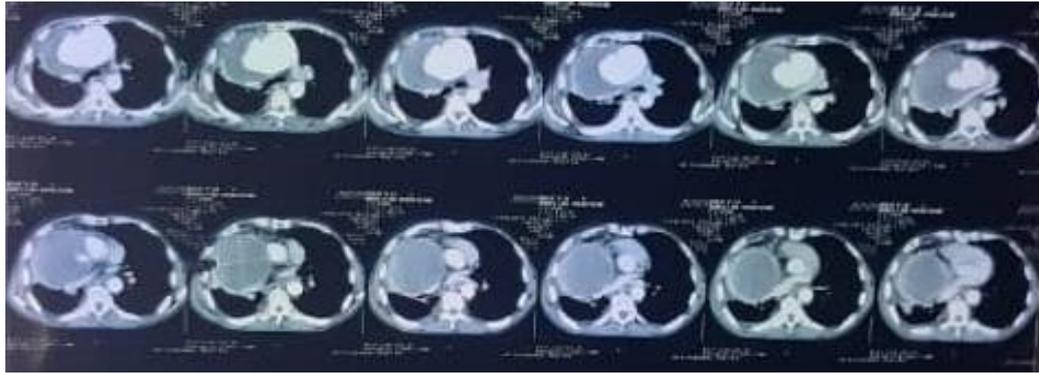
Thoracic CT scan: Giant aneurysm of the ascending aorta
